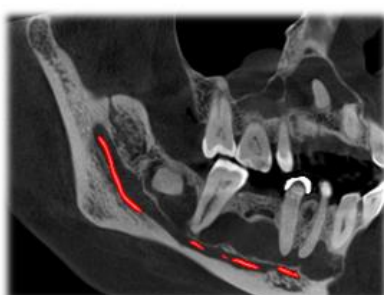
CBCT scan (Coronal section)
